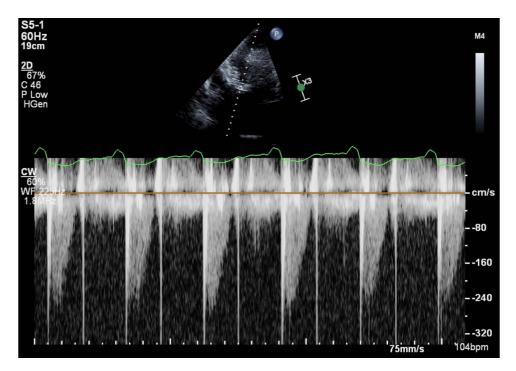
continuous-wave (CW) Doppler in apical five-chamber view showing peak velocity of 2.4 m/s.
